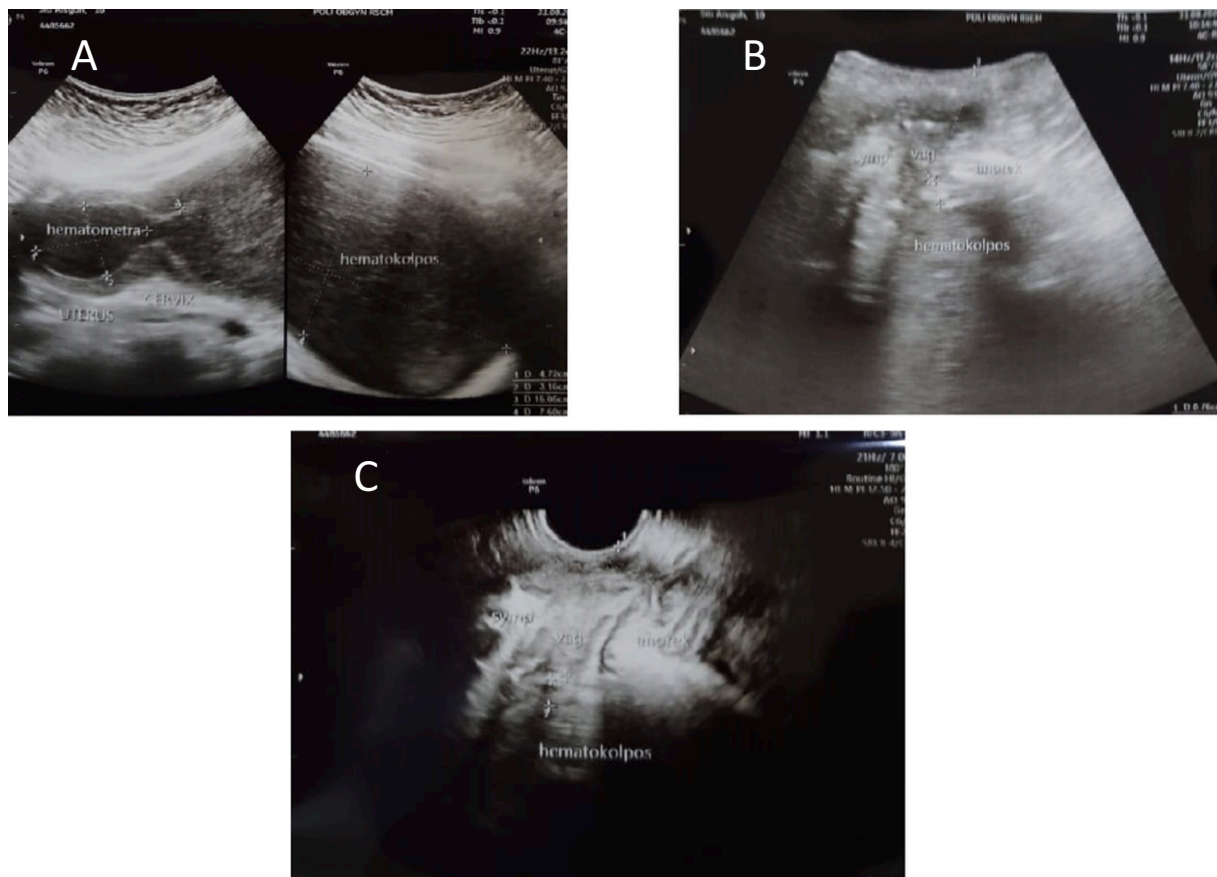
(A) Abdominal ultrasound, (B) Transperineal ultrasound, (C) Transrectal ultrasound.
